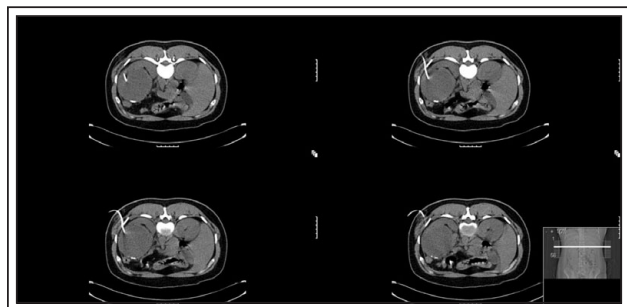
CT-guided percutaneous drainage of the renal cyst with a vacuum-assisted drain left in situ.
